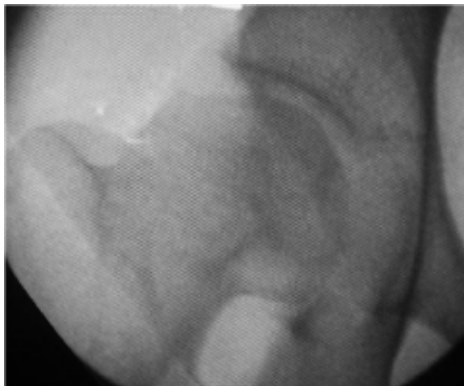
Radiograph of the right hip of the patient with stage IIb avascular necrosis of the femur.
